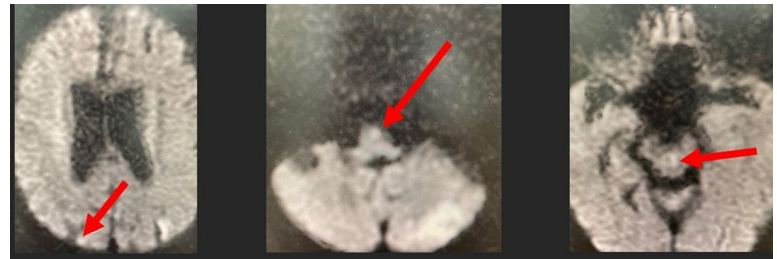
Brain MRI showed multiple areas of acute ischemia (red arrows).
